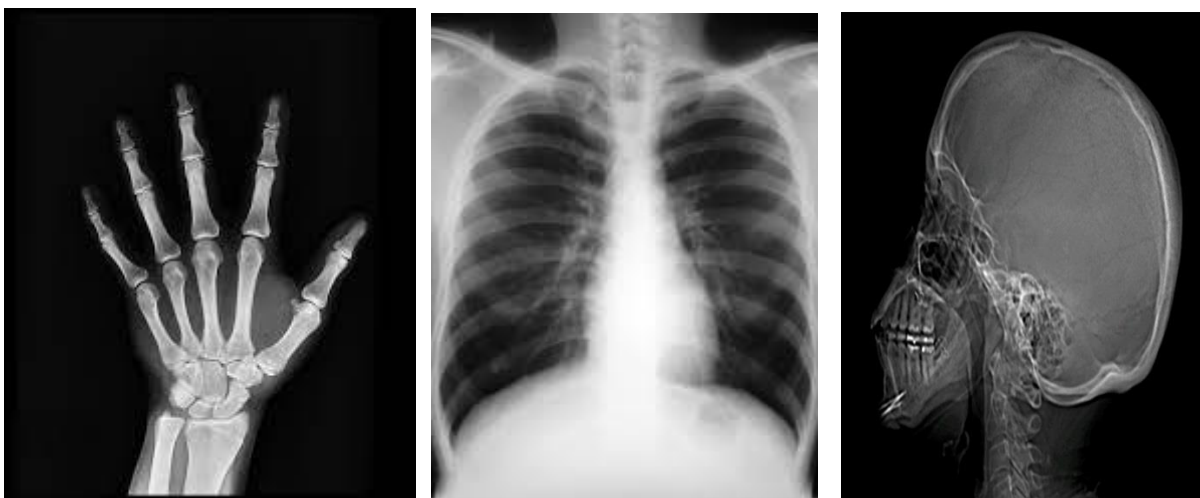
9. Examples of X-Ray examination in radiology (hand ,Thorax, skull)
